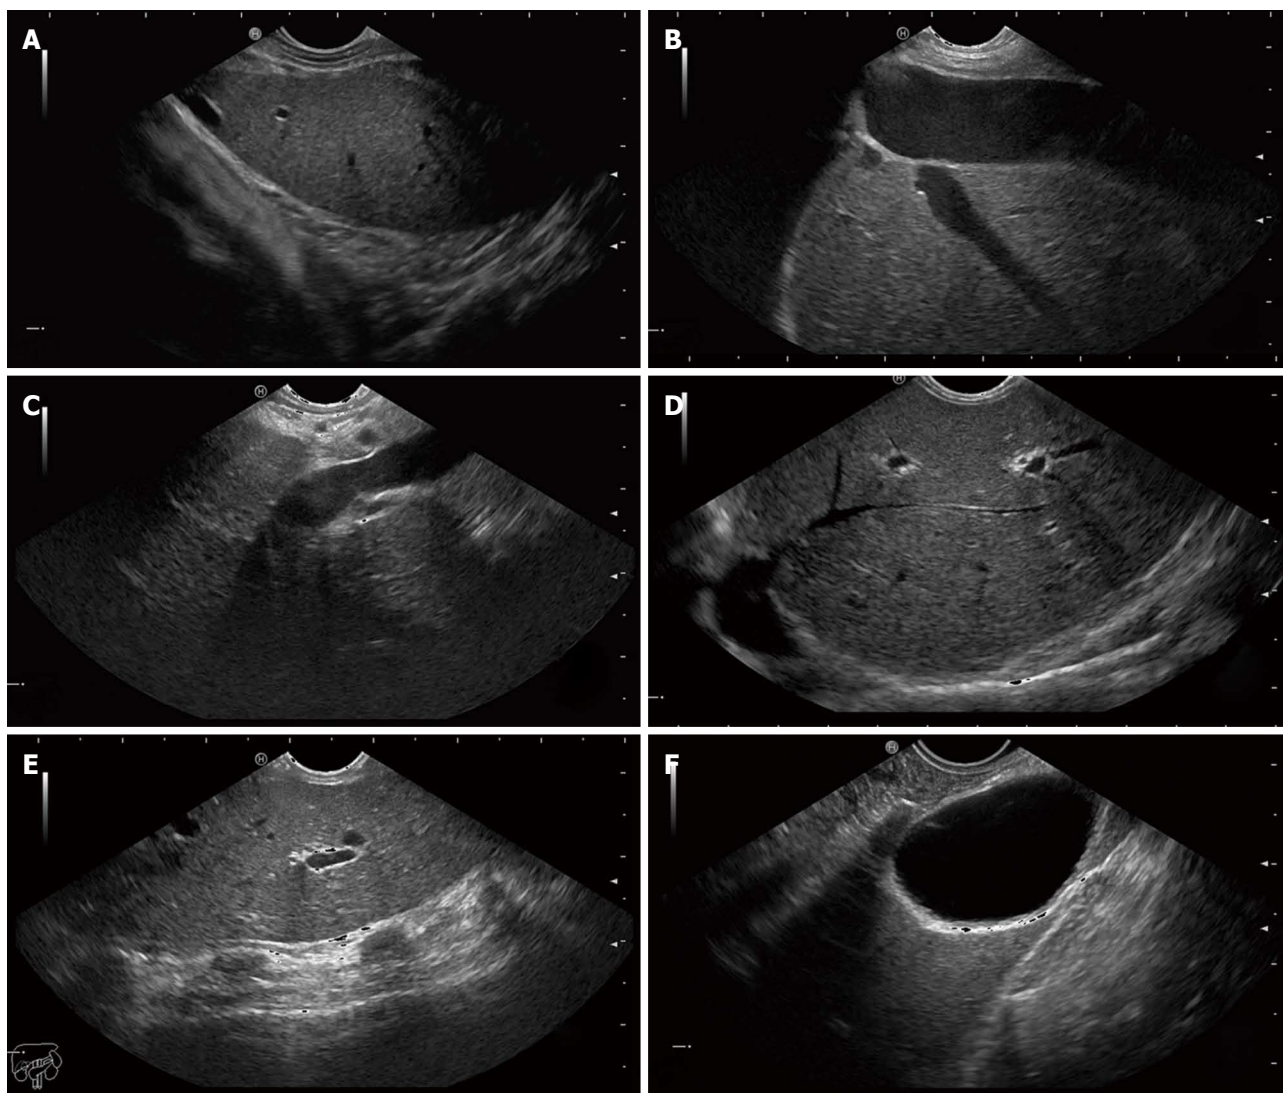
Endoscopic ultrasound images of the hepatic structures with the tip of the linear echoendoscope at different positions. A: Endoscopic ultrasound (EUS) image of the left liver lobe with the diaphragm. The image is obtained from the cardia region; B: EUS image of the left liver lobe with the inferior vena cava and a hepatic vein; C: EUS image of the liver at the portal ligament region showing from the transducer, the hepatic artery, the portal vein and a short segment of the common bile duct. The transducer is located in the stomach; D: EUS image of the liver looking over the hepatic dome; E: EUS image of the right hepatic lobe. Note the shadows from the ribs at the anterior abdominal wall; F: EUS image of the liver with the gall bladder. The transducer is located in the first part of the duodenum.
